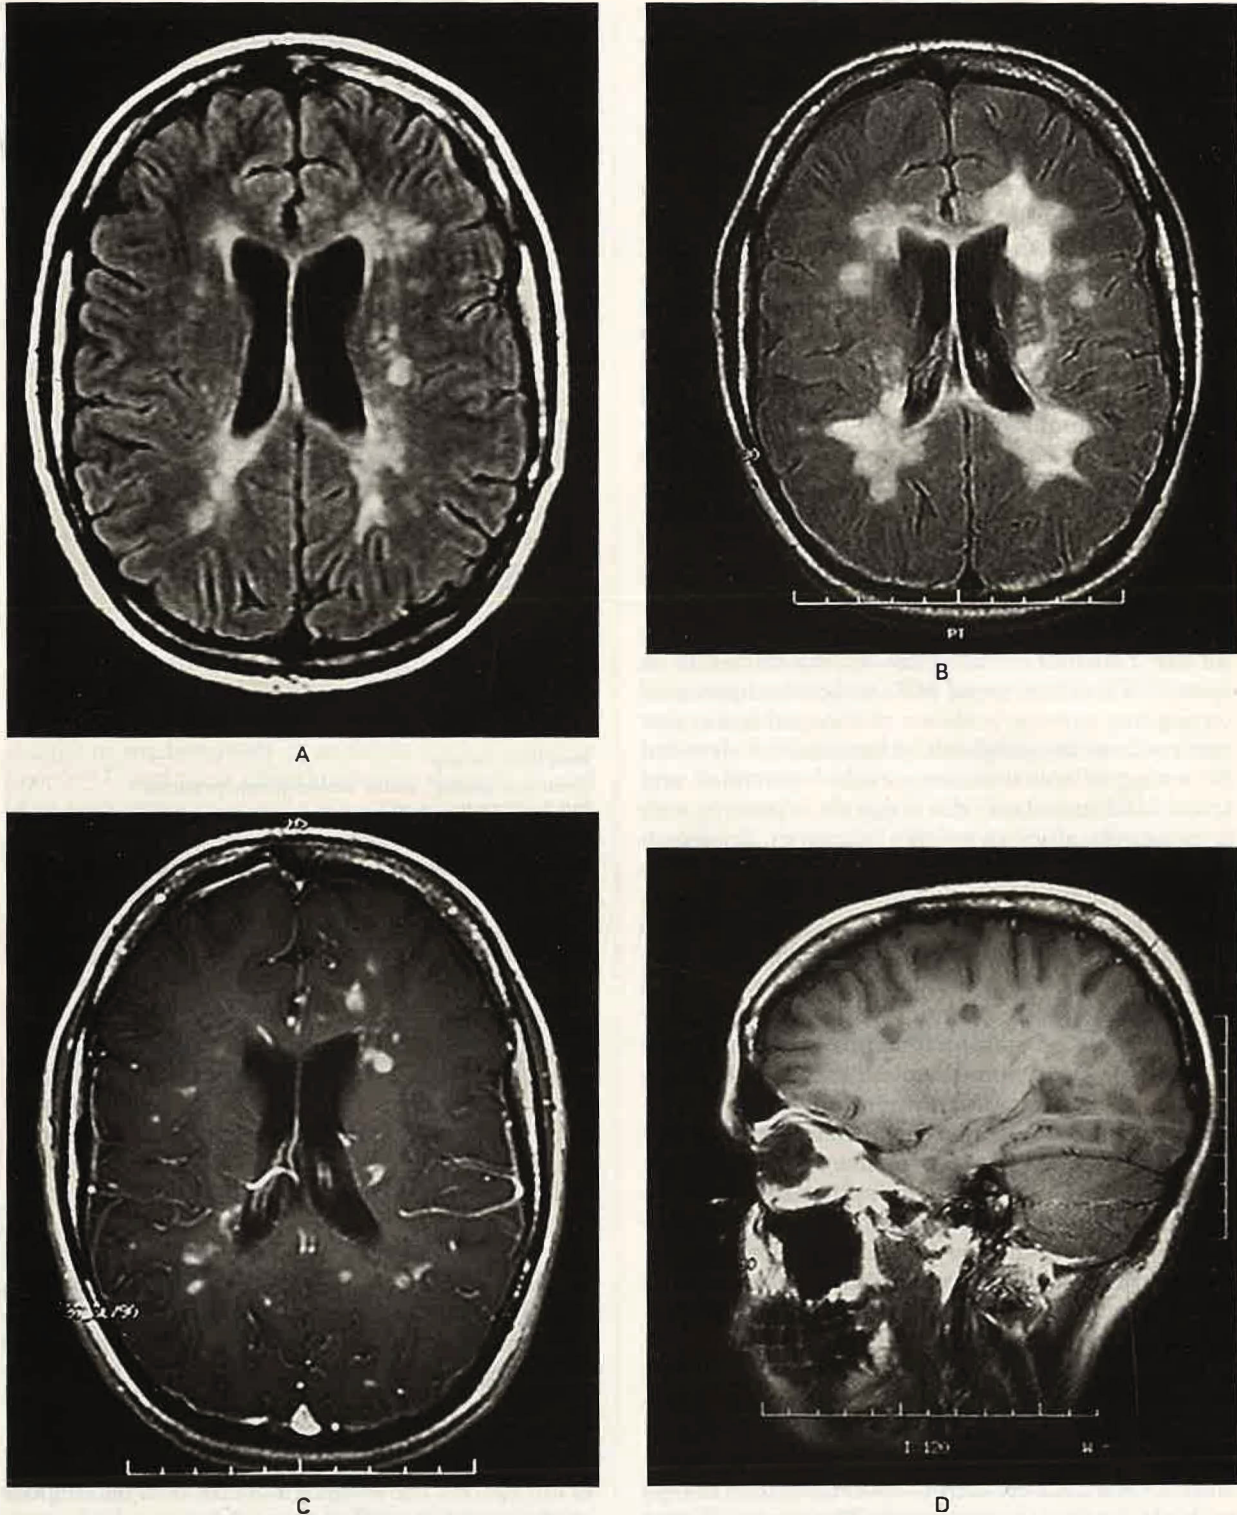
MRI Scans of the Brain of a 25-Year-Old Woman with Relapsing-Remitting Multiple Sclerosis. An axial FLAIR (fluid-attenuated inversion recovery) image shows multiple ovoid and confluent hyperintense lesions in the periventricular white matter (Panel A). Nine months later, the number and size of the lesions have substantially increased (Panel B). After the administration of gadolinium, many of the lesions demonstrate ring or peripheral enhancement, indicating the breakdown of the blood-brain barrier (Panel C). In Panel D, a parasagittal T₁-weighted MRI scan shows multiple regions in which the signal is diminished (referred to as “black holes”) in the periventricular white matter and corpus callosum. These regions correspond to the chronic lesions of multiple sclerosis.
